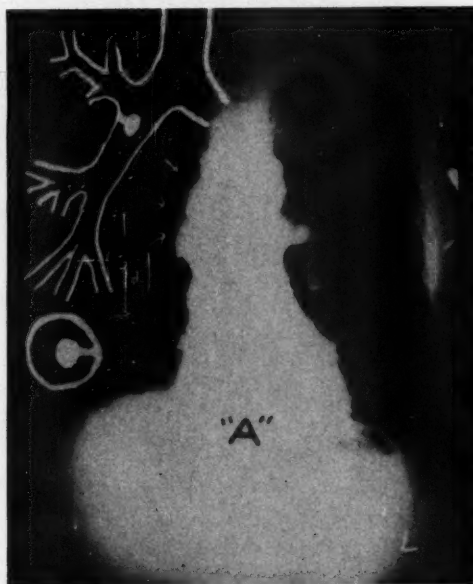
Roentgenogram of Patient "A" showing mediastinal tumor, presumably a dermoid. Inset shows bronchoscopic findings of an inflammatory polyp of the right bronchus.
